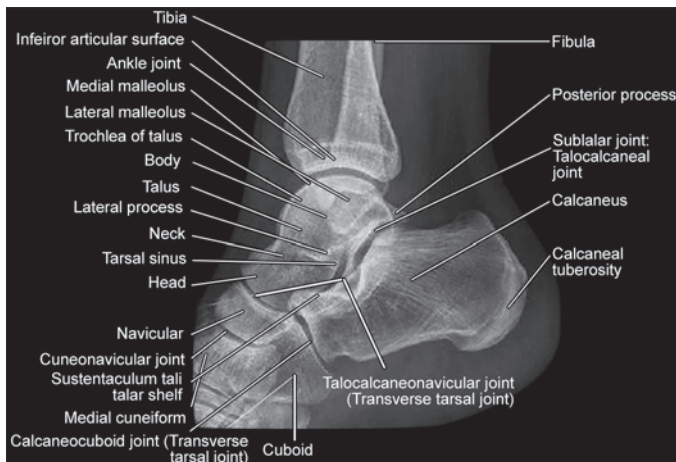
X-ray of ankle region—lateral view
